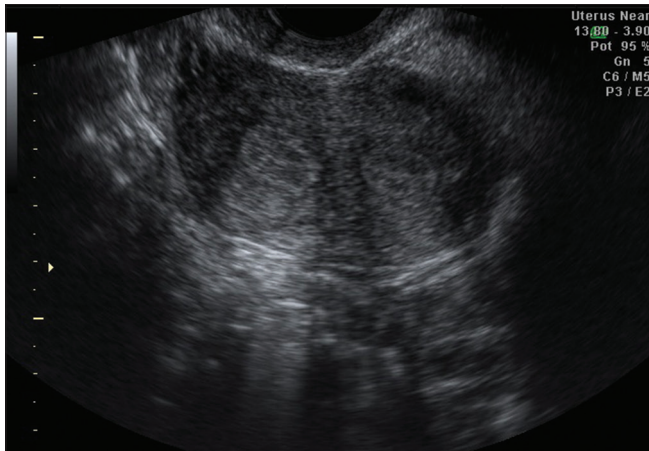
Ultrasound image showing the two uteri of the patient
